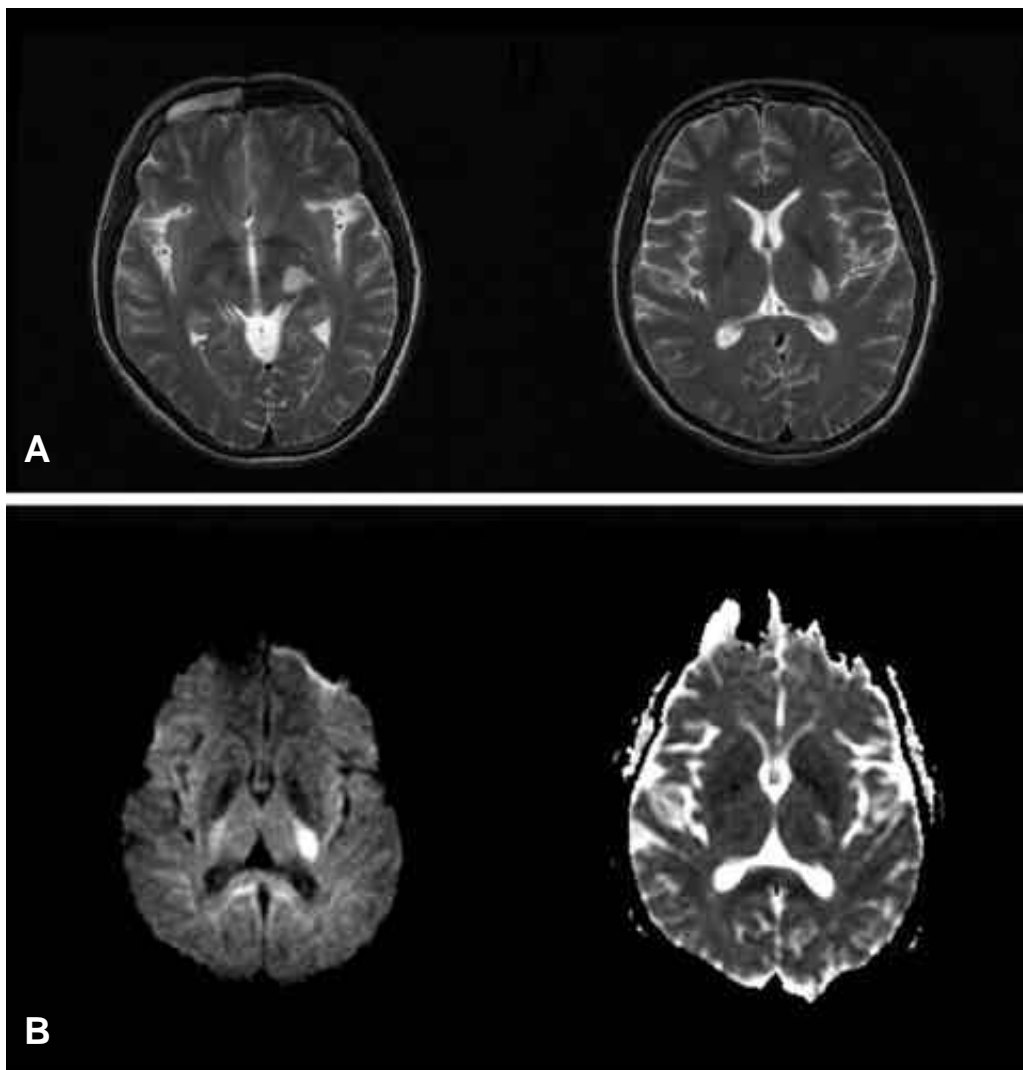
(A) Two days after the first symptom, T2-weighted image showed high signal intensity from internal capsule, thalamus to cerebral peduncle in the left side, longitudinally. (B) These longitudinal lesions were detected as high signal intensity in diffusion MR imaging with increased apparent diffusion coefficient (ADC).
